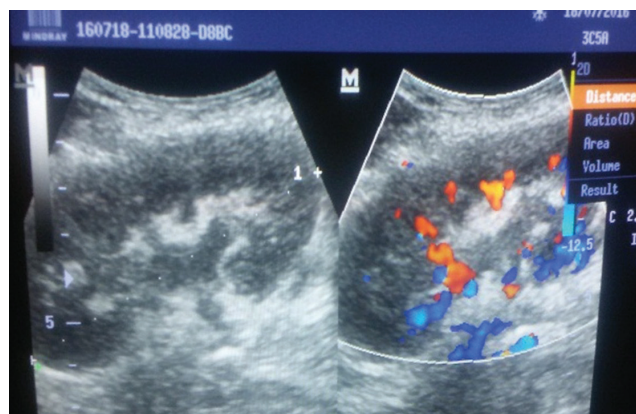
A sonogram of transplanted kidney measuring 8.87cm length with reduced CMD and dilated pelvicalyceal system.
